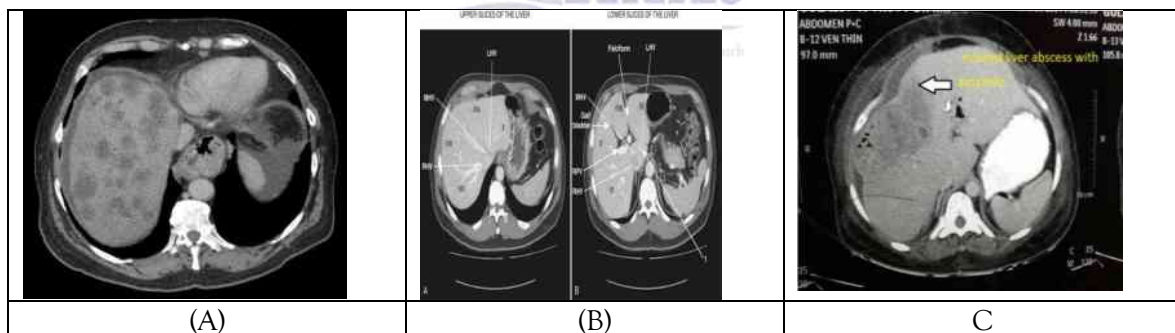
(A) shows axial image of liver CT, (B) shows Sagittal view of liver CT, (C) shows Coronal view of liver CT
